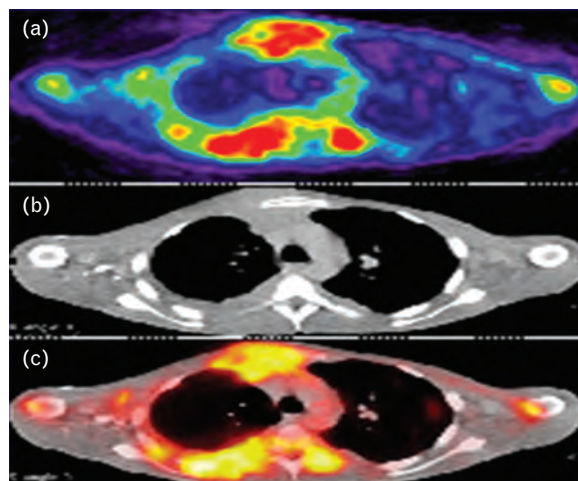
A 28-year-old man with a large right-sided pleural effusion and mycobacterium tuberculosis on pleural fluid analysis. Dual-time point imaging was performed at 60 min and 120 min following ^{68}Ga -citrate injection (224 MBq, IV) and IV contrast. (a) Transaxial section shows intense tracer accumulation in the anterior chest wall and posterior thickened pleura on the right. (b) Corresponding transaxial computed tomography (CT) section. (c) PET/CT-fused transaxial section showing the changes.
